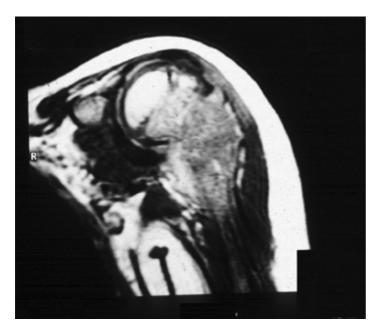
Ewing Sarcoma of the proximal humerus (MRI)
